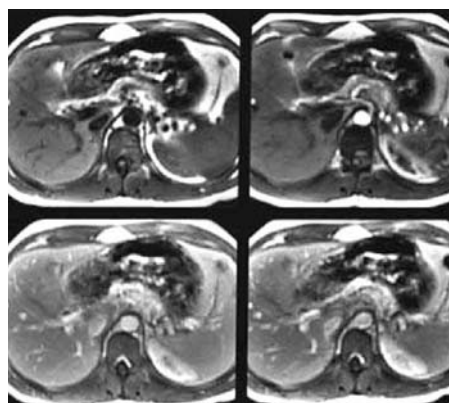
Multiple breath-hold T1-weighted GRE (FLASH TR 150, TE 4.4, FA 80) sequences acquired following a gadolinium-DTPA bolus. Each set of 24 images was acquired during a different phase of hepatic perfusion. Precontrast, upper left; arterial phase, upper right; portal phase, lower left; delayed phase, lower right.
